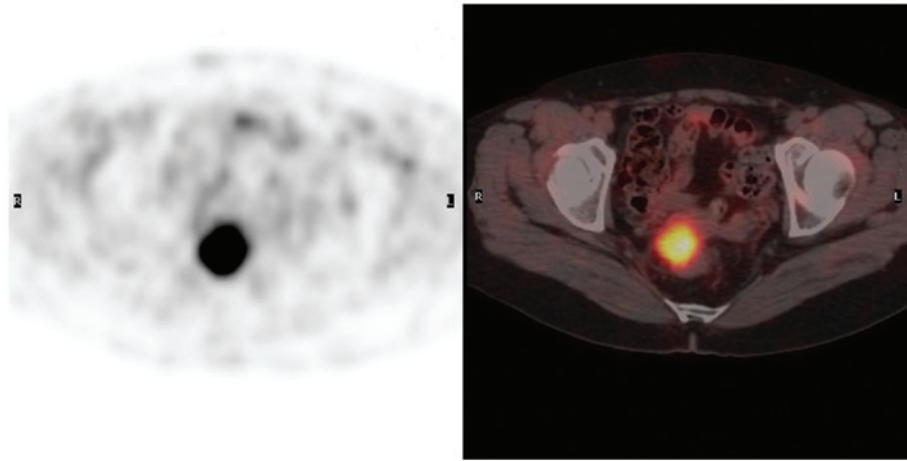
Pre-operative transaxial PET (left) and fused PET/computed tomography (right) slices demonstrating intense ^{18}F -fluorodeoxyglucose uptake (standardized uptake value, 10.0) in the rectum, measuring 38.2x31.3 mm, consistent with metastasis. PET, positron emission tomography.
